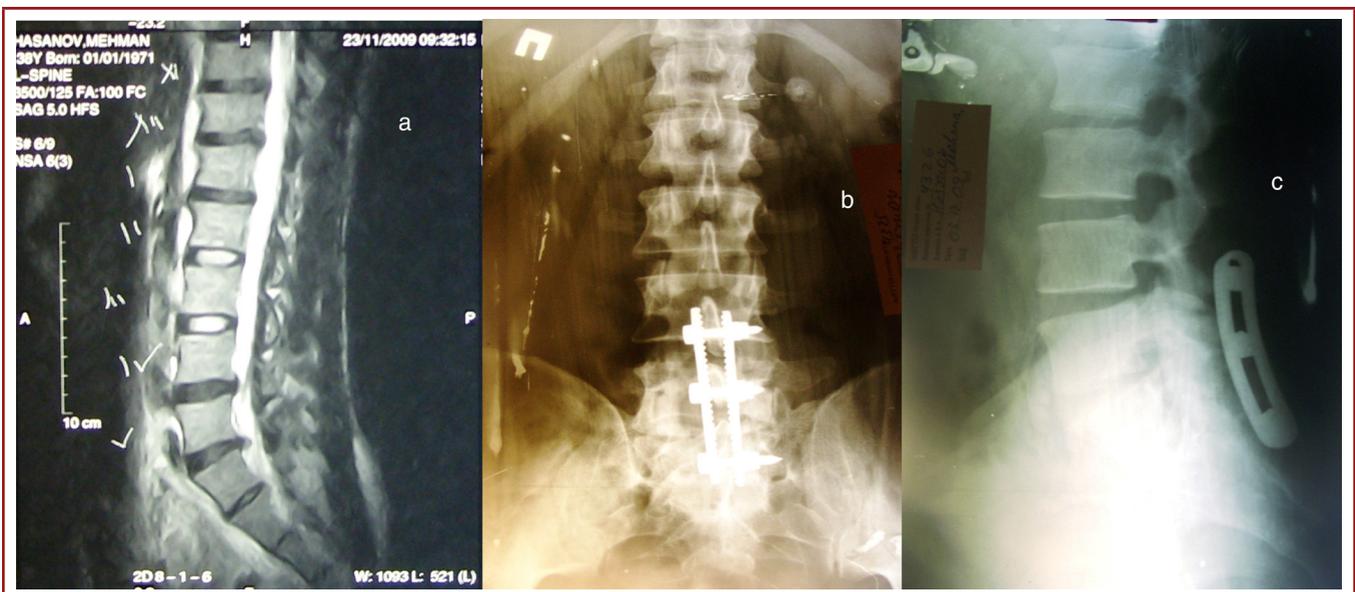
MR and X-ray pictures of the patient M.H. (38 years old) with prolapsed two disks:- *a)* MRT films of the low back region before the operation; *b)* X-ray picture low back region after the operation of implantation in side projection; *c)* X-ray picture low back region after the operation of implantation in direct projection.
